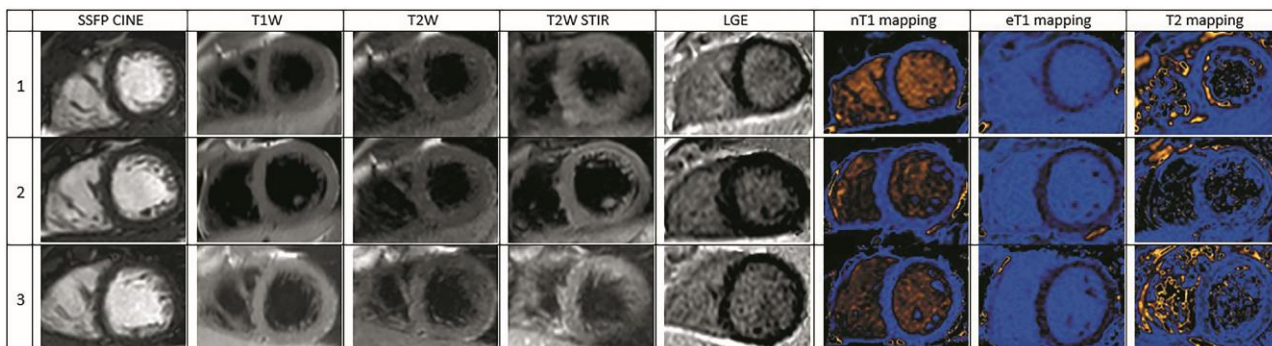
Serial cardiac magnetic resonance (CMR) imaging performed on admission day (1), 2 weeks (2), and 6 months (3). The figure shows steady-state free precession imaging (SSFP CINE), T1-weighted imaging (T1W), T2-weighted imaging (T2W), T2-weighted short-tau inversion recovery imaging (T2W STIR), late gadolinium enhancement imaging (LGE), native T1 mapping (nT1 mapping), enhanced T1 mapping (eT1 mapping), and T2 mapping.
